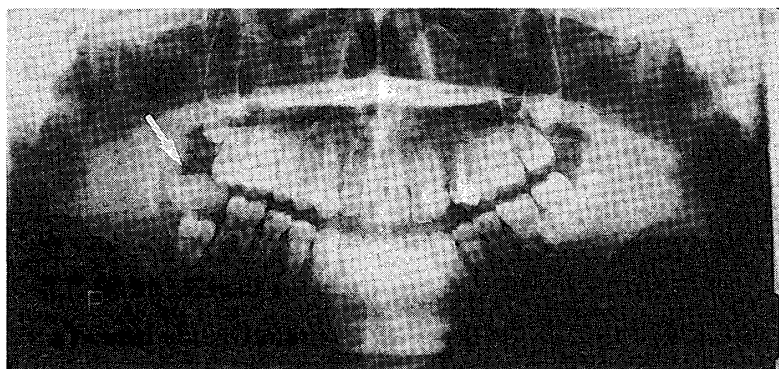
Radiographic image of the lesion showing an oval-shaped radiopaque mass in the right mandible of the patient.
